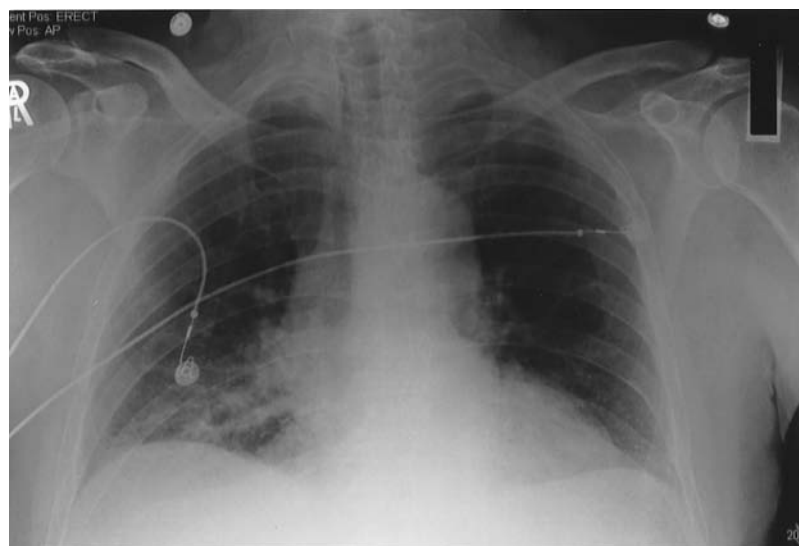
Chest radiograph showing consolidation of right lower zone extending from mediastinum.
